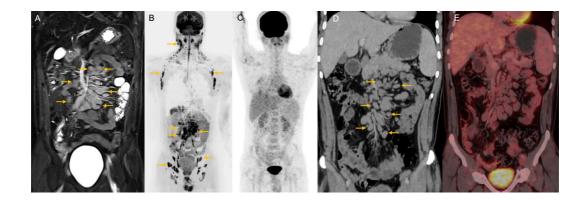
Stage IV on both WB-MRI and PET-CT. A. Coronal STIR image showing multiple enlarged STIR hyperintense para-aortic and mesenteric nodes (yellow arrows). B. Coronal MIP DWI image showing multiple diffusion-restricting enlarged nodes in the cervical, axillary, liver hilar, para-aortic, mesenteric, iliac and inguinal stations. C. Coronal MIP PET image does not show significant lymphadenopathy. D. Coronal CECT image showing multiple enlarged, homogeneously enhancing periportal and mesenteric lymph nodes (yellow arrow). E. Corresponding PET-CT fused images do not show significant FDG uptake in the enlarged lymph nodes.
